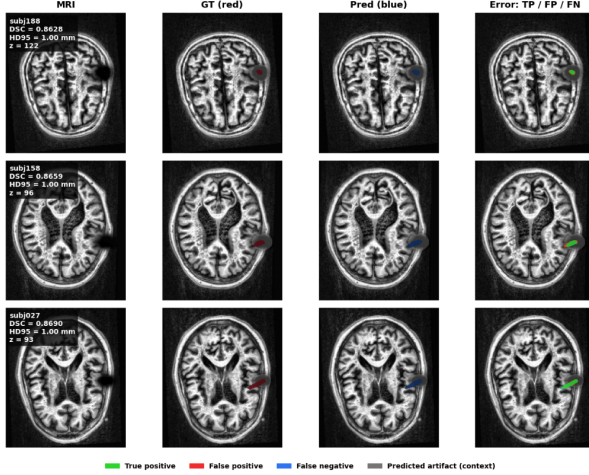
Task B validation results for three subjects. Columns show axial MRI slice, ground-truth catheter mask (red), predicted catheter mask (blue), and error map with true positive, false positive, false negative, and predicted artifact context.
